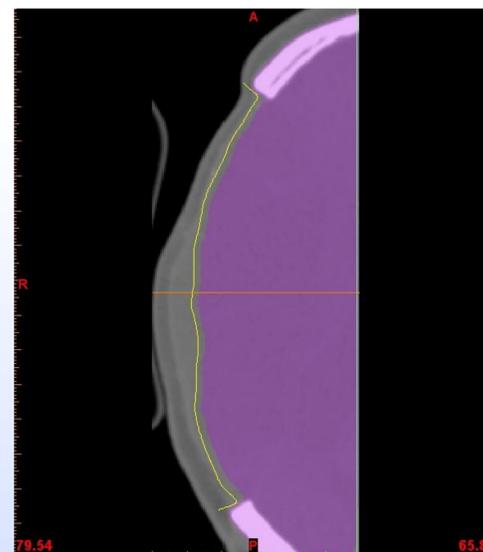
comparison of 3D scan of end produced sterilized CranioTool with CT-data as general approval (pink: bone and brain/dura tissue, yellow: 3D scanned inner surface of the presurgical in CranioTool kneaded PMMA calotte)
